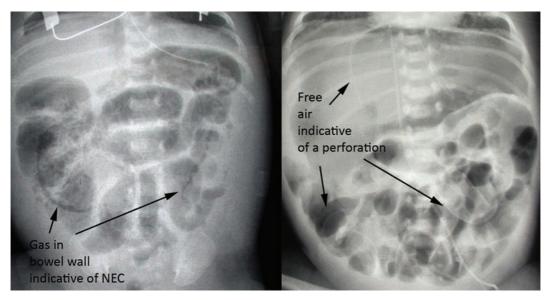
5 X-ray of a premature baby with necrotizing enterocolitis and free air indicating a perforation.
